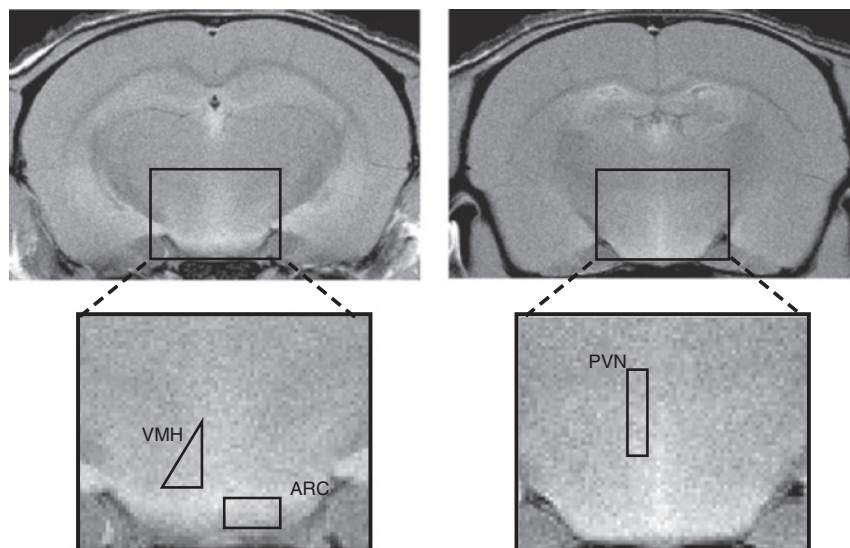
Regions of interest (ROIs) used in MEMRI analysis. MR image showing the ROI locations in the hypothalamus from which SI measurements were determined. ARC, arcuate nucleus; MEMRI, manganese-enhanced magnetic resonance imaging; MR, magnetic resonance; PVN, paraventricular nucleus; SI, signal intensity; VMH, ventromedial hypothalamus.
